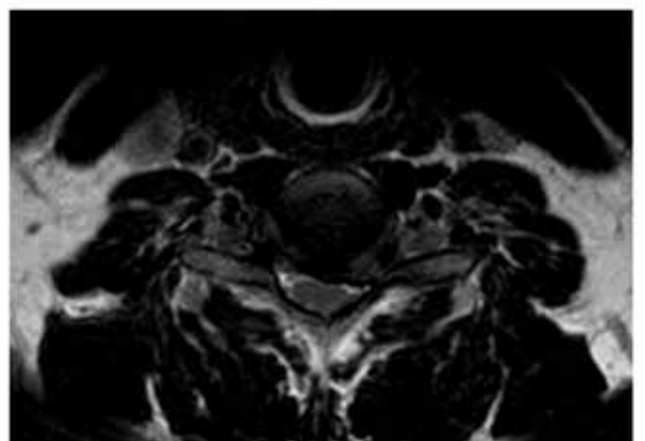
MRI Cervical spine, T2-weighted sagittal and axial sequences
